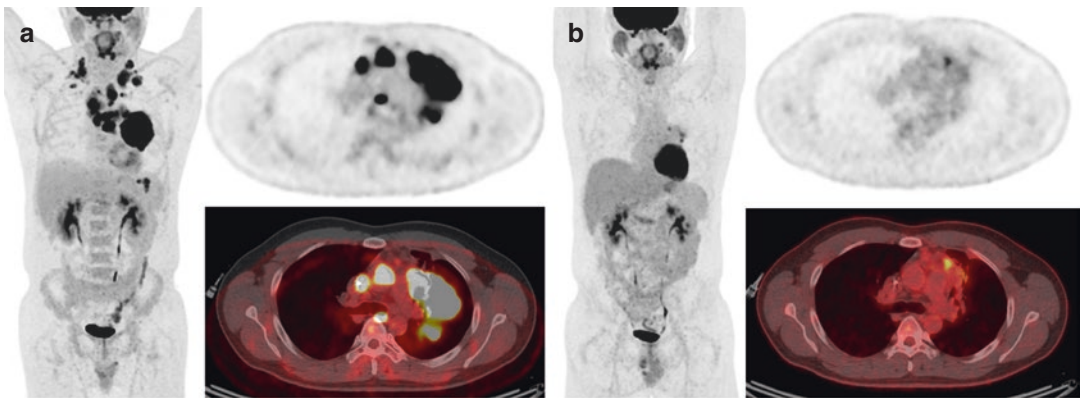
32-year-old man with classical Hodgkin lymphoma. (a) Baseline FDG-PET/CT showed intensely FDG-avid bilateral cervical and mediastinal lymph nodes consistent with metabolically active lymphoma. (b) After 2 cycles of ABVD chemotherapy, several focal areas of residual increased FDG uptake greater than the liver were
